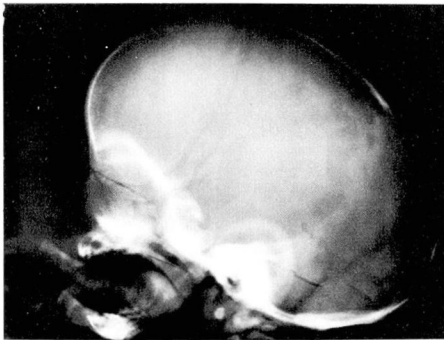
Lateral roentgenogram of skull with sagittal craniosynostosis. Note foreshortening of frontal fossa and apparent elevation of orbital roof.
